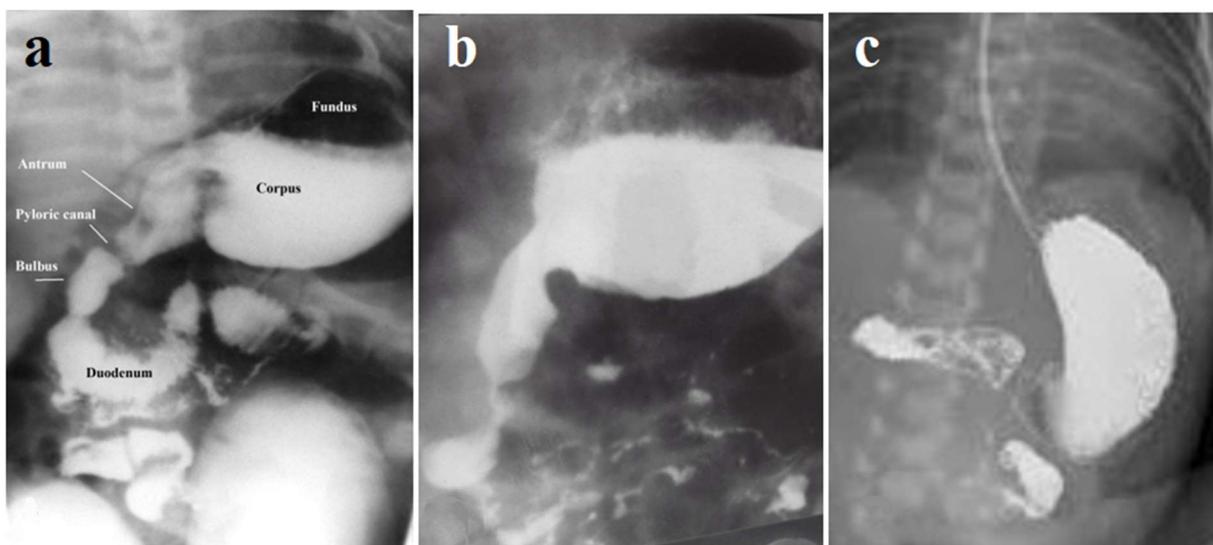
The gastroduodenal radiographs in infants up to 1 month of age. (a, b) Infants with regurgitation. (c). Newborn with malrotation.
